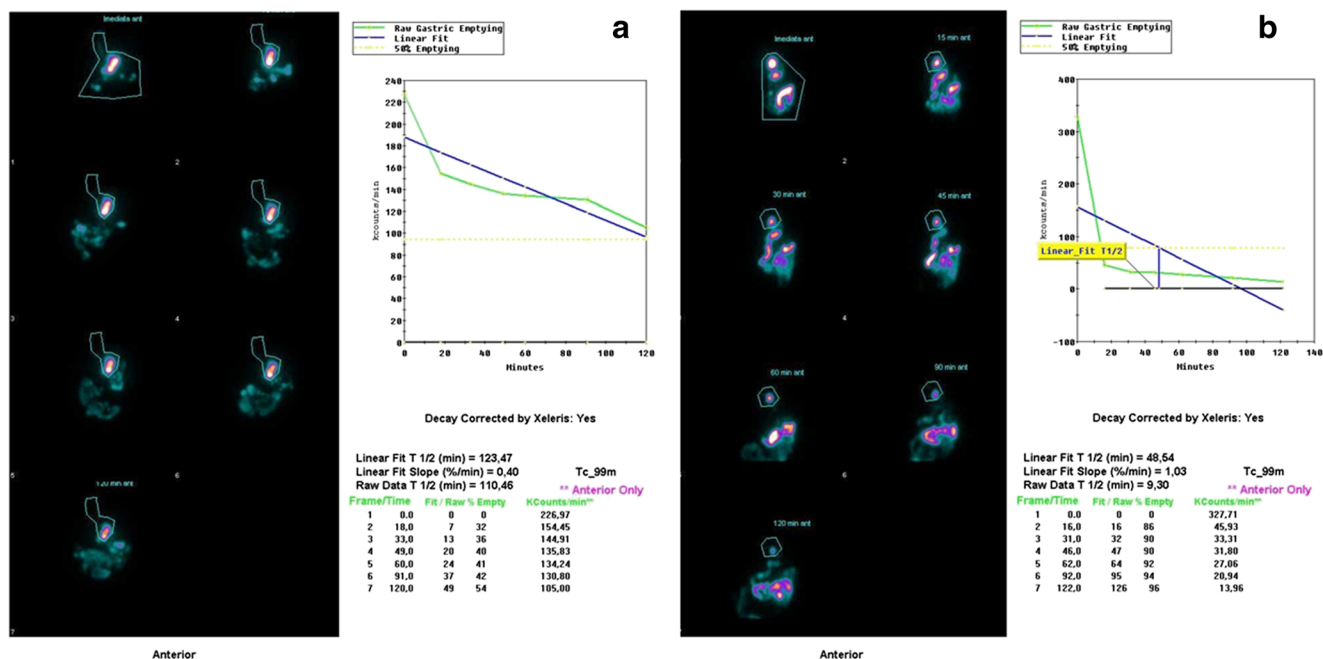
a Gastric emptying scintigraphy in a patient who had undergone RYGB (Case no. 51); b Gastric emptying scintigraphy in a patient who had undergone BRYGB (Case no. 03)
